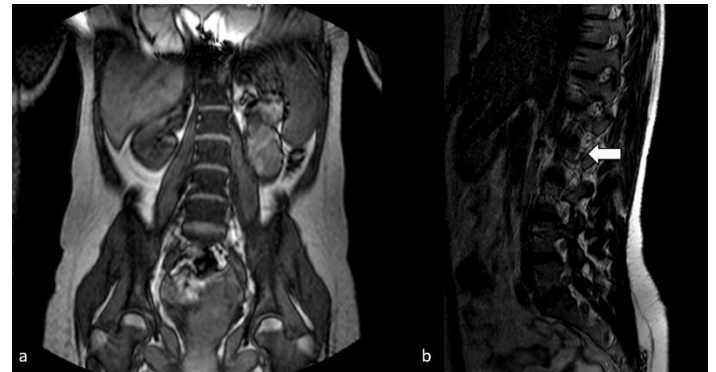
Coronal lumbar survey image (a) showing the scoliosis and T2-weighted sagittal image (b) of the same patient. Not all the vertebrae are on the same line because of scoliosis, also showing the suspected apex of the curvature (arrow).
